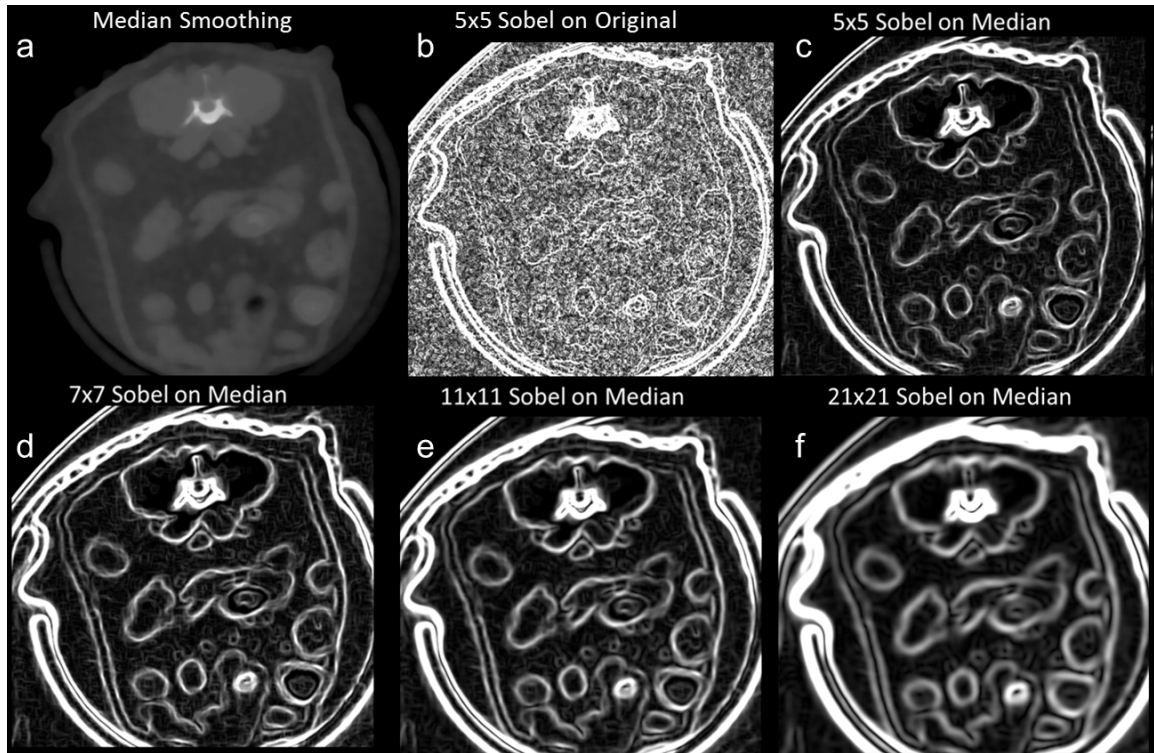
a) Median filter applied onto a raw CT volume, b) 5x5 Sobel operator applied onto raw CT volume and Sobel operator of sizes c) 5x5, d) 7x7, e) 11x11, and f) 21x21 applied onto 3D 15x15x3 Median filtered volumes.
